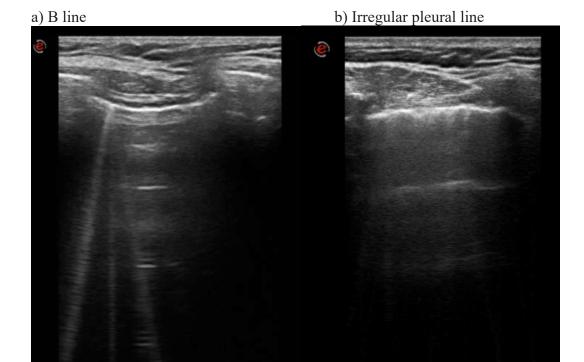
Lung ultrasound showing B-lines and pleural irregularities.
